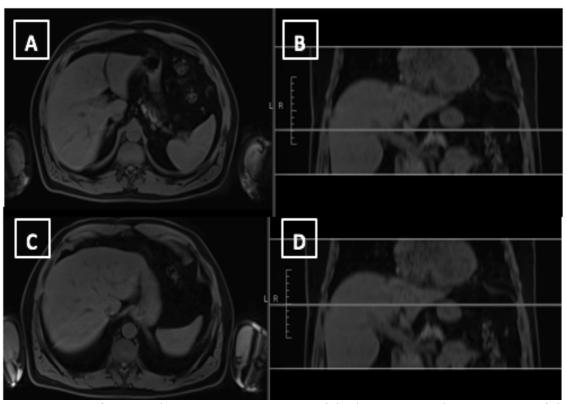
Inferior and posterior MRI images of the liver. Coronal MRI images of the abdomen B and D with the horizontal line depicting the location of the axial MRI images A and C, respectively.
